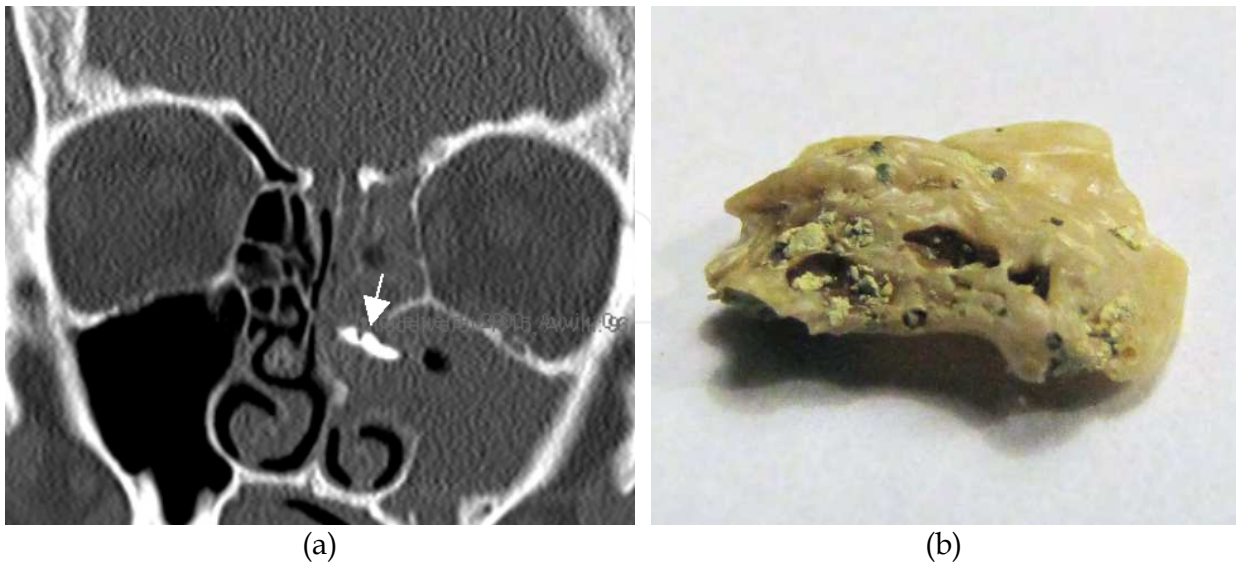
(a) Coronal CT shows advanced opacification of the left ethmoid and maxillary sinuses as in OMC inflammatory pattern. However, the inflammatory changes are due to an elongated calcification (arrow) located in the middle meatus. (b) A few months later, the patient delivered an ectopic molar tooth.
